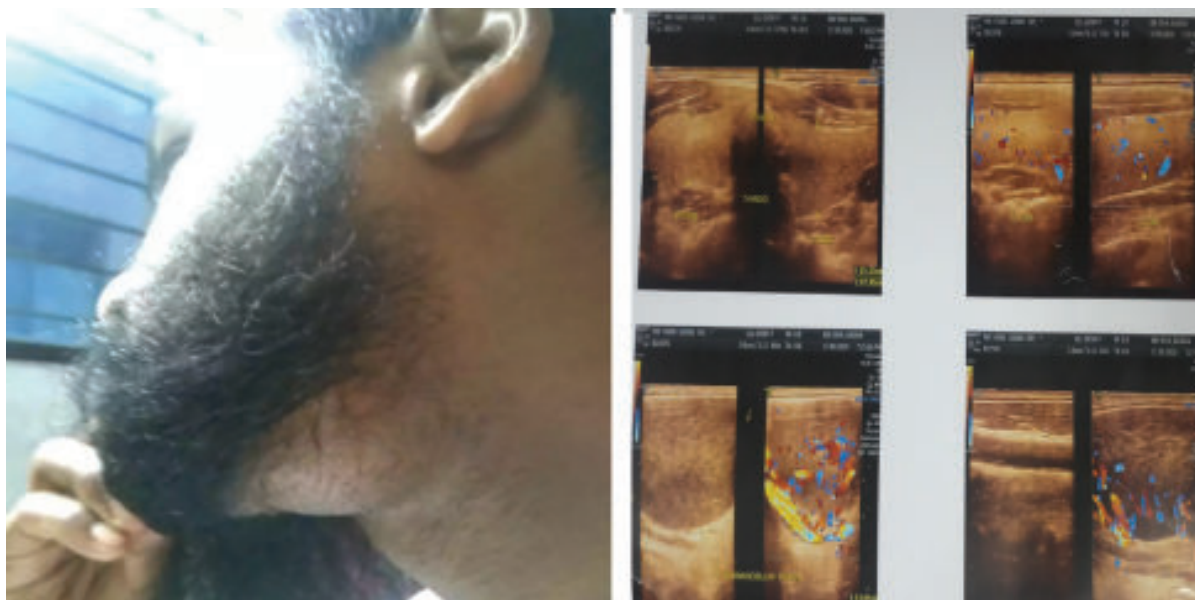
Swelling at submandibular region measuring collectively (3 cm x 2.5 cm x 2 cm) and large solid mass in the left submandibular region in ultrasonography
